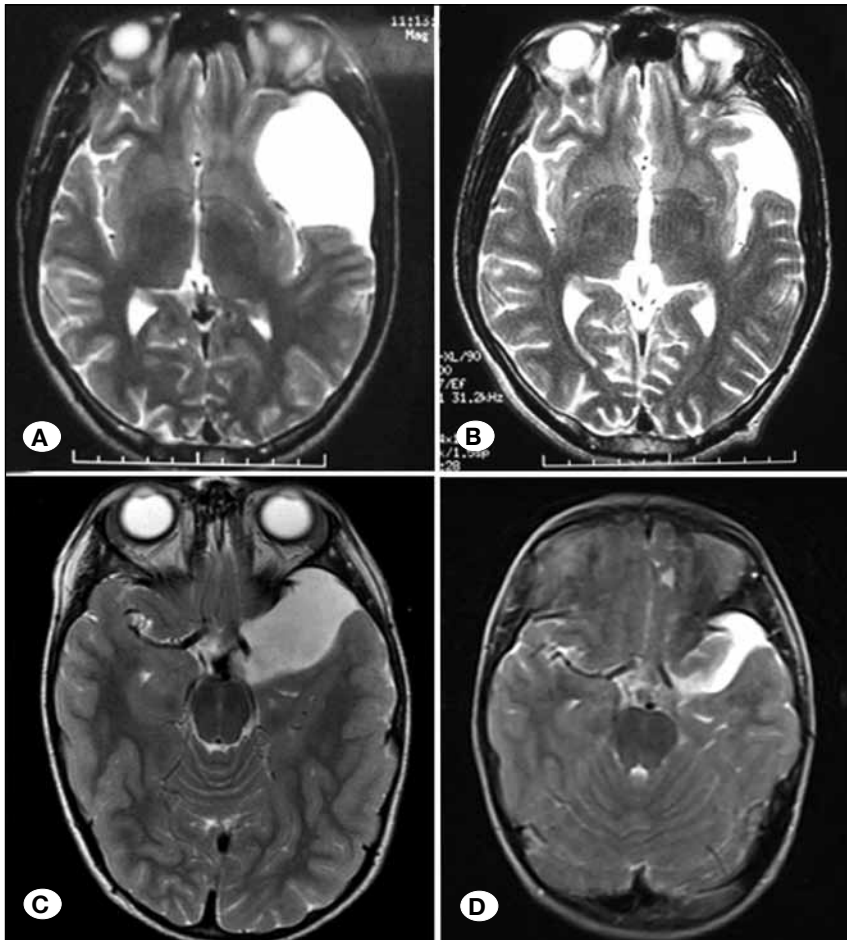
A) Preoperative T2 weighted axial image of 16 years old boy with Galassi type III left temporal arachnoid cyst. B) 6-month postoperative image of the same patient showing marked decrease in cyst volume. C) Preoperative T2-weighted axial image of a 6-year-old boy with Galassi type II left temporal arachnoid cyst. D) 18-month postoperative image of the same patient with reduced cyst volume.
